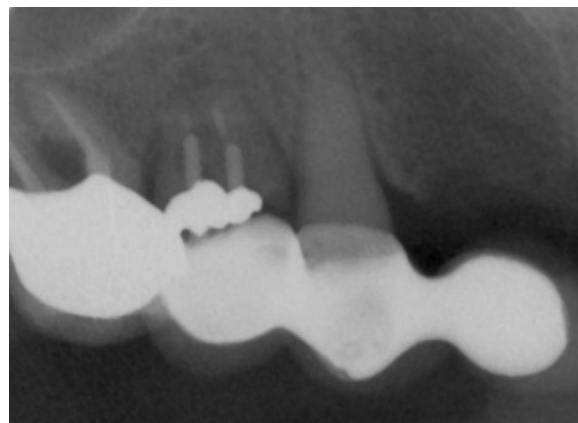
In this radiograph of a cantilevered fixed partial denture, mesial marginal decay is observed on the right second premolar, at an area of high bending stress, since this area is distal from the cantilever fulcrum. Continuous micro-cracking stresses at the mesial surface of the abutment facilitated plaque and carbohydrate retention, and decay
